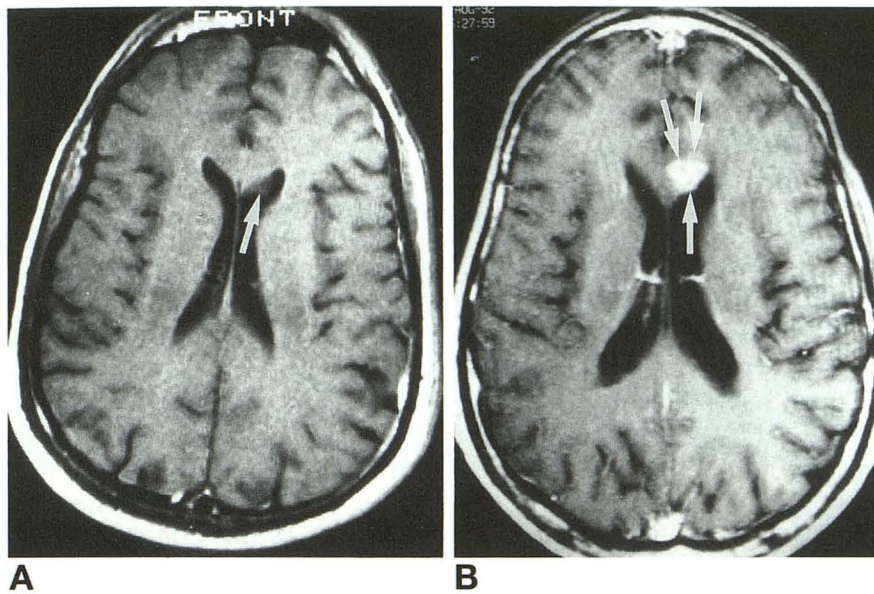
MR images of a 42-year-old man obtained 12 days before surgery (A) and 2 years after surgery (B).
